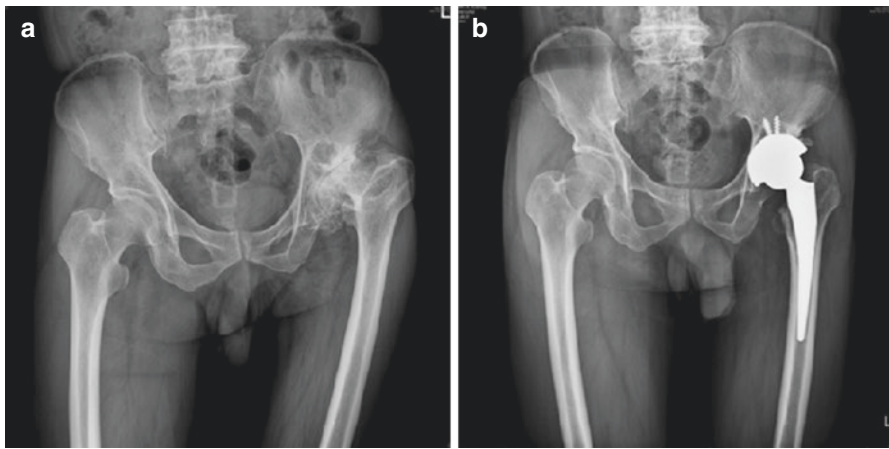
A 62-year-old man had left DDH with high riding femur and LLD 4 cm due to childhood trauma (a). Radiograph taken 1 year after superomedial placement of the cup and THA showed good position and bone ingrowth of the implant and restoration of leg length (b) (these pictures were agreed by the patient for publication)
